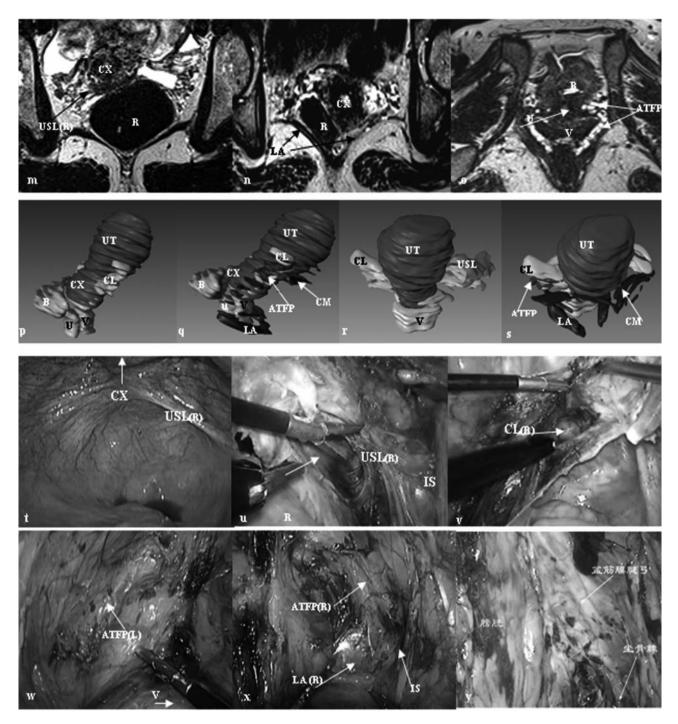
MRI, MRI 3D models and the intraoperative detection of laparoscope demonstrate the relations between the USL, CL, uterus, IS and ATFP in a 43- year-old woman with uterine prolapse. Panel m, MRI demonstrates the left USL detached from cervix; it is difficult to identify the origin. Panel n, MRI demonstrates the left LA avulsion and split. Panel o, MRI demonstrates compared to the right, the left ATFP with a larger grid gap. Panel p, MR3D model shows from left side, the left USL that is absent. Panel q, MR3D model shows from left side, the relations between uterus, CM, ATFP (blue), and LA, and relations between ATFP, cervix, vagina, and urethra. ATFP shape is thin and weak, with attachment to cervix which is not compact, and vaginal side suspension is weak. Panel r, MR3D model as seen from behind. Panel s, MR3D model from left behind demonstrates the relations between uterus, ATFP, and LA. Panel t, the intraoperative detection of laparoscope demonstrates the left USL detached from cervix; it is difficult to asses the origin. The right USL is clearly seen. Panel u, dissection shows the right USL origined from IS. Panel v, the intraoperative detection of the right ATFP detachment from the ischial spine.
